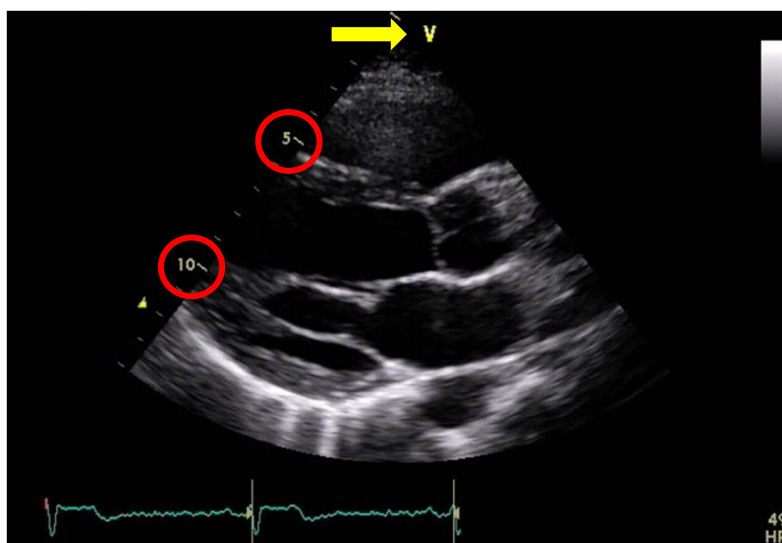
Ultrasound image in the parasternal long-axis view. The image shows the correct screen orientation with the marker (yellow V) to the right of the ultrasound sector
